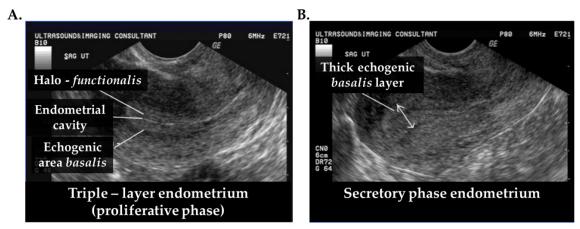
Ultrasound images of a normal human endometrium. A. Trilaminar appearance of the endometrium during the proliferative phase with and outer surrounding echogenic basalis layer and hypoechoic and darker inner functional layer, separated by a thin echogenic median layer arising from the endometrial cavity. B. During the secretory phase the endometrium appears even thicker and more echogenic. Image adapted with permission from www.fetalultrasound.com.
